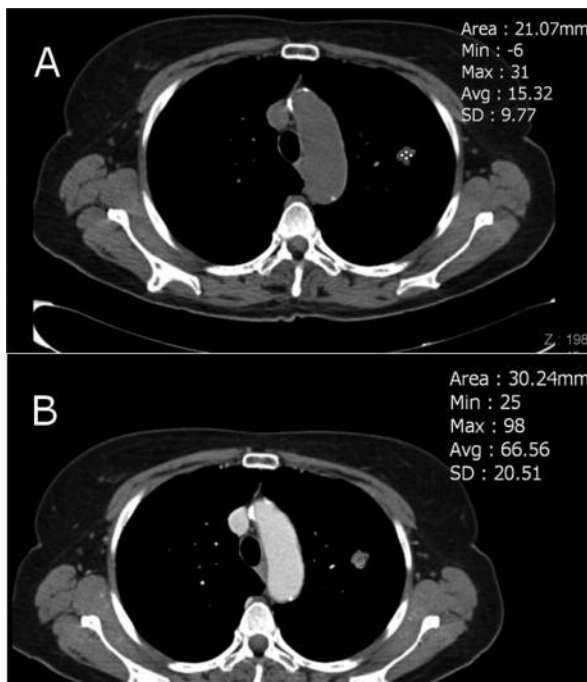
Chest CT, showing in the anterior segment of the left upper lobe a nodular solid formation with irregular margins, characterized by contrast enhancement, with max dimensions of 17 mm x 16 mm. A, Pre-contrast scan; B, Post-contrast scan.
